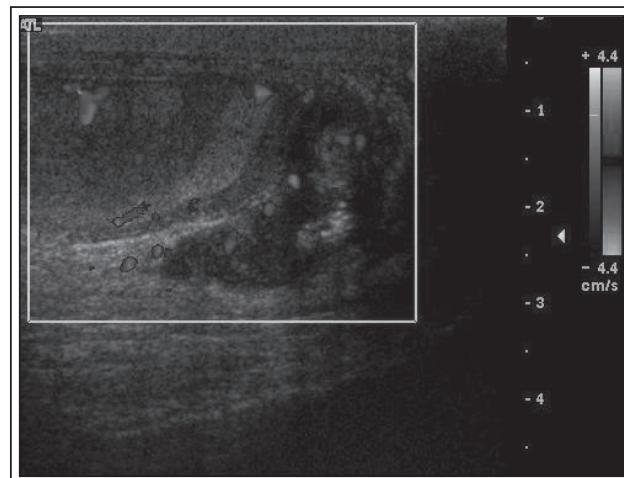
Doppler ultrasound demonstrating a thickened, hypervascular epididymis and normal testicle.
